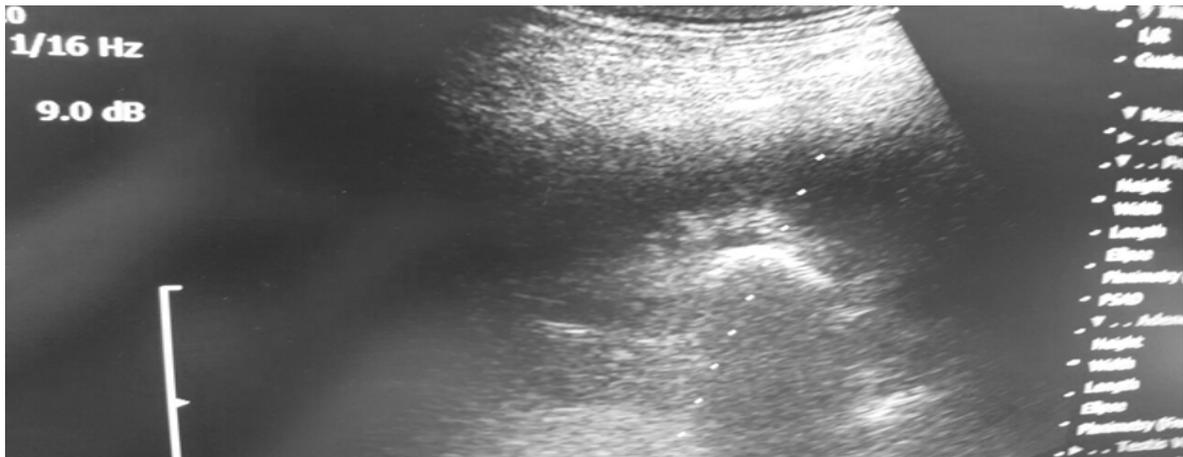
Ultrasonography shows large right renal pelvic stone
